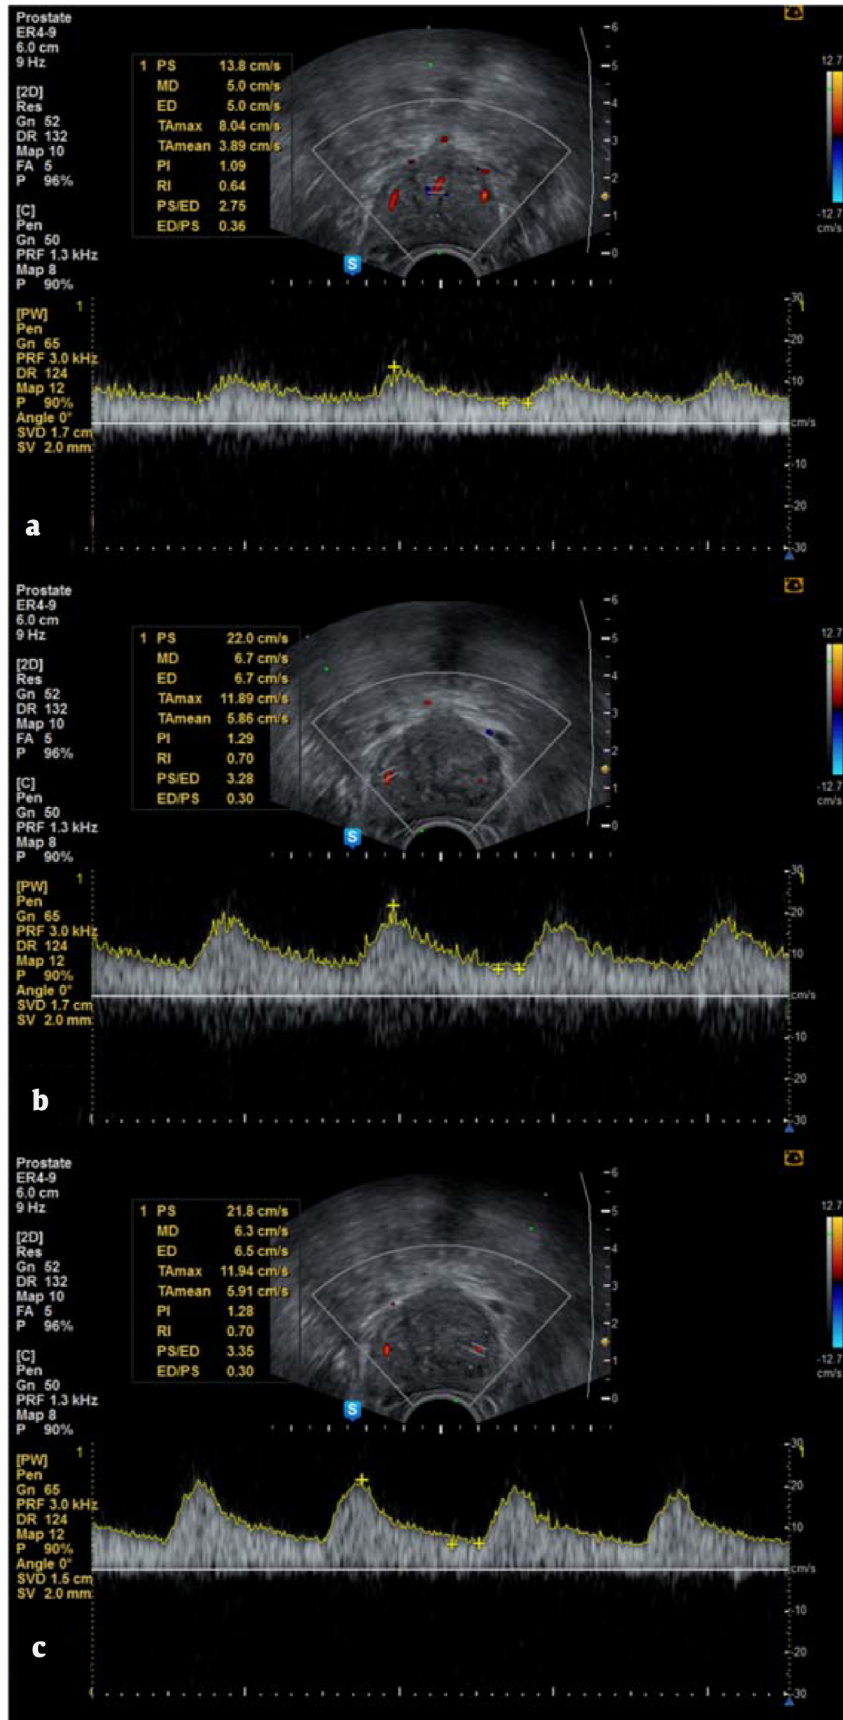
Color Doppler ultrasonogram of a patient with benign prostatic hyperplasia and resistive index measurement. (A) Urethral artery, (B) right capsular artery, and (C) left capsular artery.
